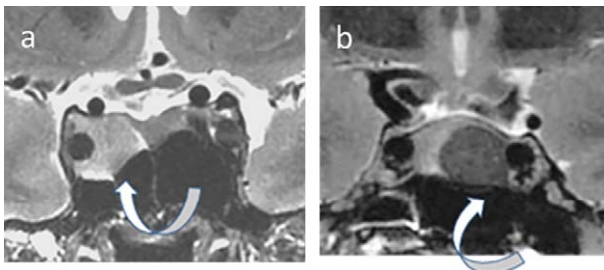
Hyperintense (a) and hypointense (b) GH-secreting adenomas on T2 W MRI.
